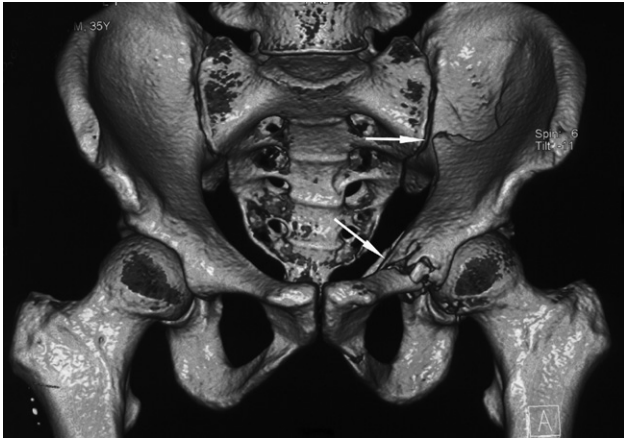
Shaded surface 3D CT reconstruction. The images can be viewed in any desired projection and give a better appreciation of the pelvis. Two fractures are demonstrated in the left innominate bone (arrows), which were hard to diagnose on plain film.
